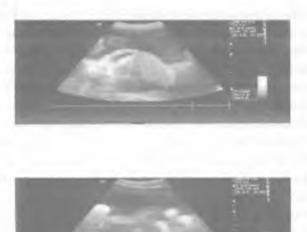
Ultrasonography of ascites
